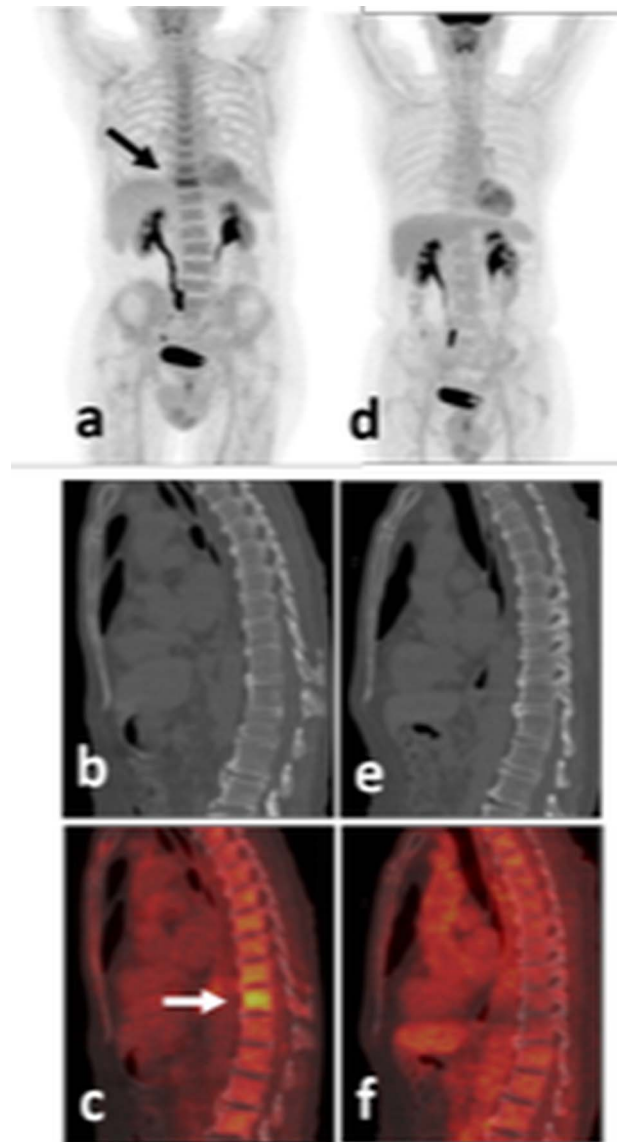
^{18}F -FDG PET/CT, baseline (a, b, c) and after 6 months of anti-TB treatment (d, e, f). (a, d) Maximum intensity projection images; (b, e) sagittal CT spine reconstruction; (c, f) fused PET/CT sagittal spine sections. Intense ^{18}F -FDG accumulation is observed in the intact body of the T11 vertebra (a, b, c, arrows), completely normalized post-treatment (d, f). Of notice the, probably reactive to the infection, moderate metabolic enhancement of the entire skeletal bone marrow at baseline (a), returning to normal post-treatment (d).
